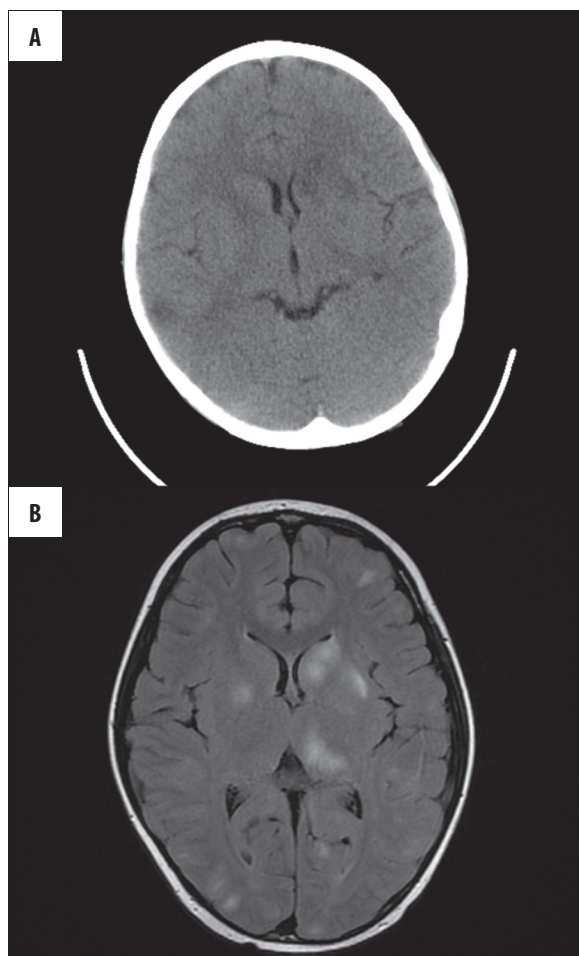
Boy BM, age 8 with diagnosis of acute lymphoblastic leukemia. CT brain examination shows ambiguous hypodense focal lesions in both hemispheres. In MRI examination these were identified as leucemic infiltration.
